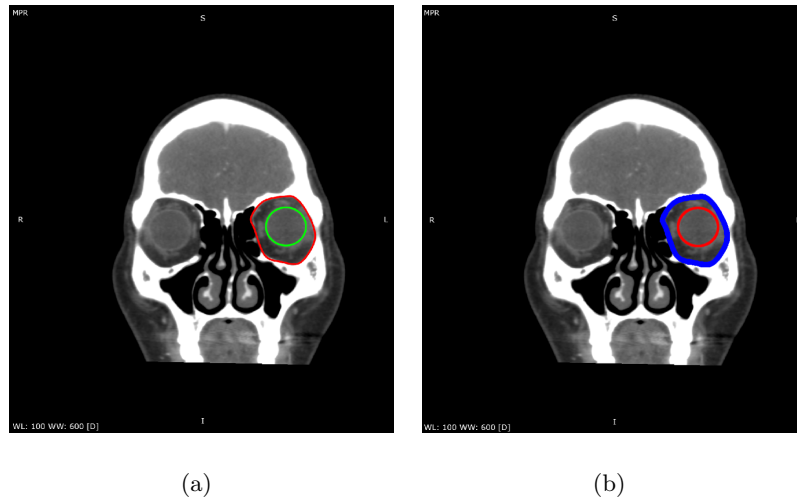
(a) Showing original CT-slice loaded in the imaging processing tool. (b) Original CT slice after both boundaries were detected and plotted onto the original slice.
